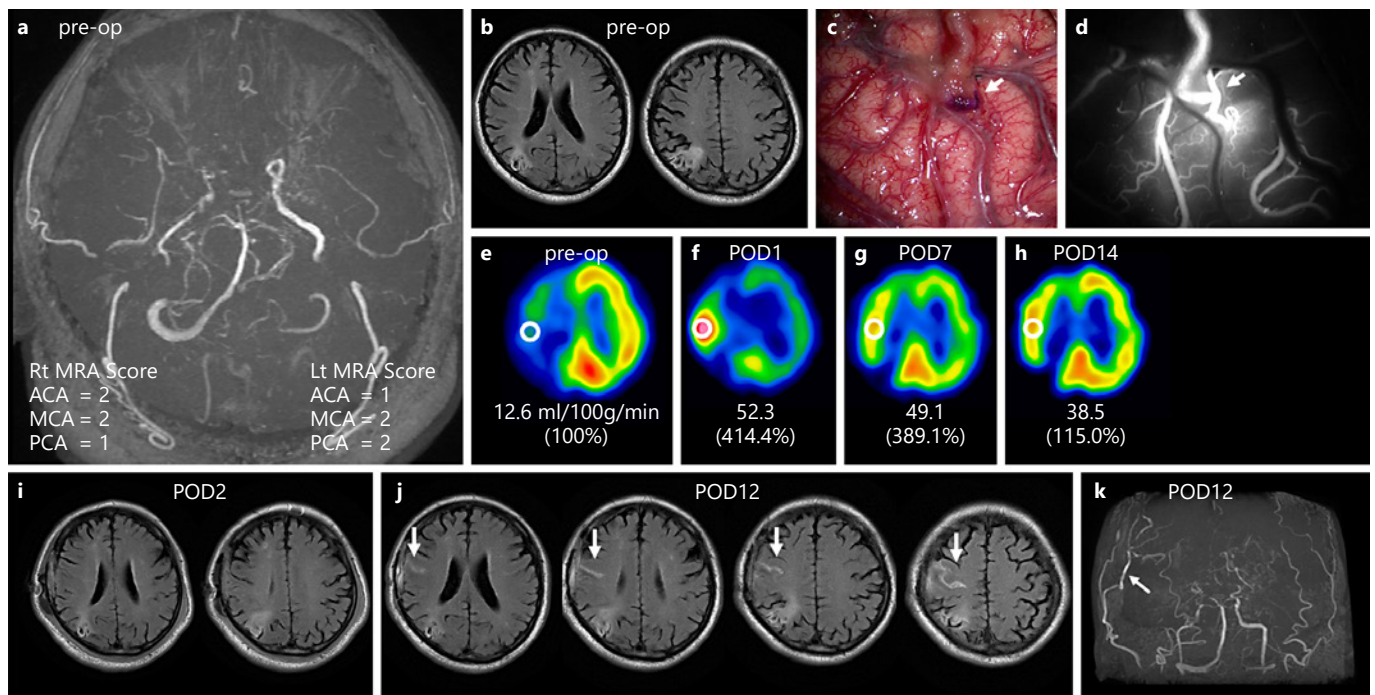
a Preoperative MRA scores for each hemisphere as grade 5, bilaterally. b FLAIR showing cerebral infarction in the right parieto-occipital lobe. c Intraoperative view of right STA-MCA anastomosis (arrow). d Indocyanine green video-angiography confirmed the patency of the bypass artery (arrow). e-h ^{123}I -IMP SPECT before (e) and 1 day (f), 7 days (g), and 14 days (h) after right STA-MCA anastomosis. The shown numbers are the quantitative local CBF values of the white circle by the auto-radiographic method. Percentages in the parenthesis indicate the relative CBF
